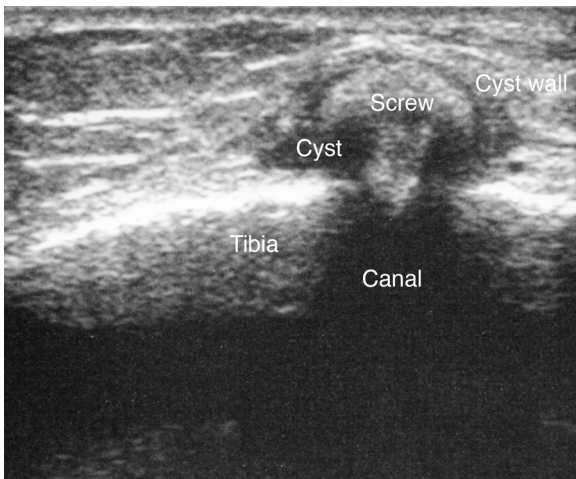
Ultrasound image of the proximal tibia in a patient approximately 3 years after an anterior cruciate ligament reconstruction using a hamstrings graft fixed distally with a bioabsorbable interference screw (BIOSURE, 9 × 30 mm) in the bone canal. The transducer is placed vertically on tibia, centred on the painful swelling. The head of the bioabsorbable interference screw (BIOSURE, 9 × 30 mm) has broken off of the rest of screw and been dislodged out of the canal. The head is situated inside a cyst-like structure.
